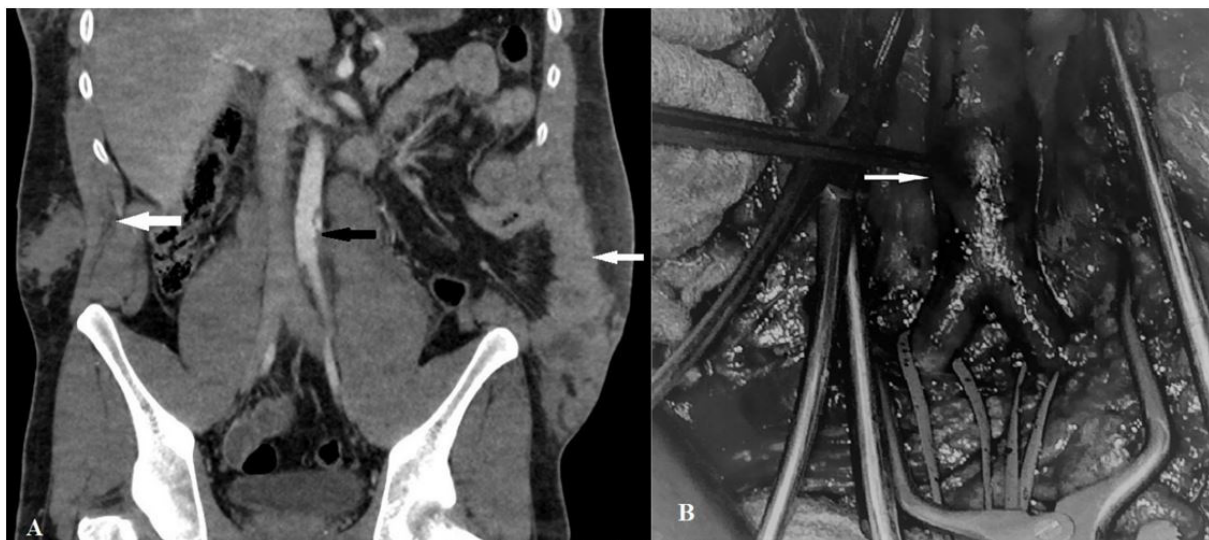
A CT images showing aortic injury (Black arrow) and two traumatic abdominal wall hernias (White Arrow). B. Intraoperative image showing external contour deformity of infrarenal aorta in zone III (White Arrow)
